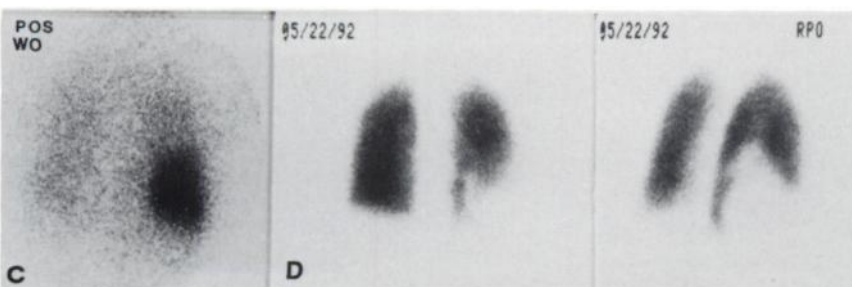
Patient 3. Paired ventilation and perfusion images obtained pre- and 15 hr post-BAL. Marked abnormalities after BAL involve multiple segments of the RLL. The chest x-ray was normal. Posterior washout ventilation images (A and C); posterior and right posterior oblique perfusion images (B and D).
